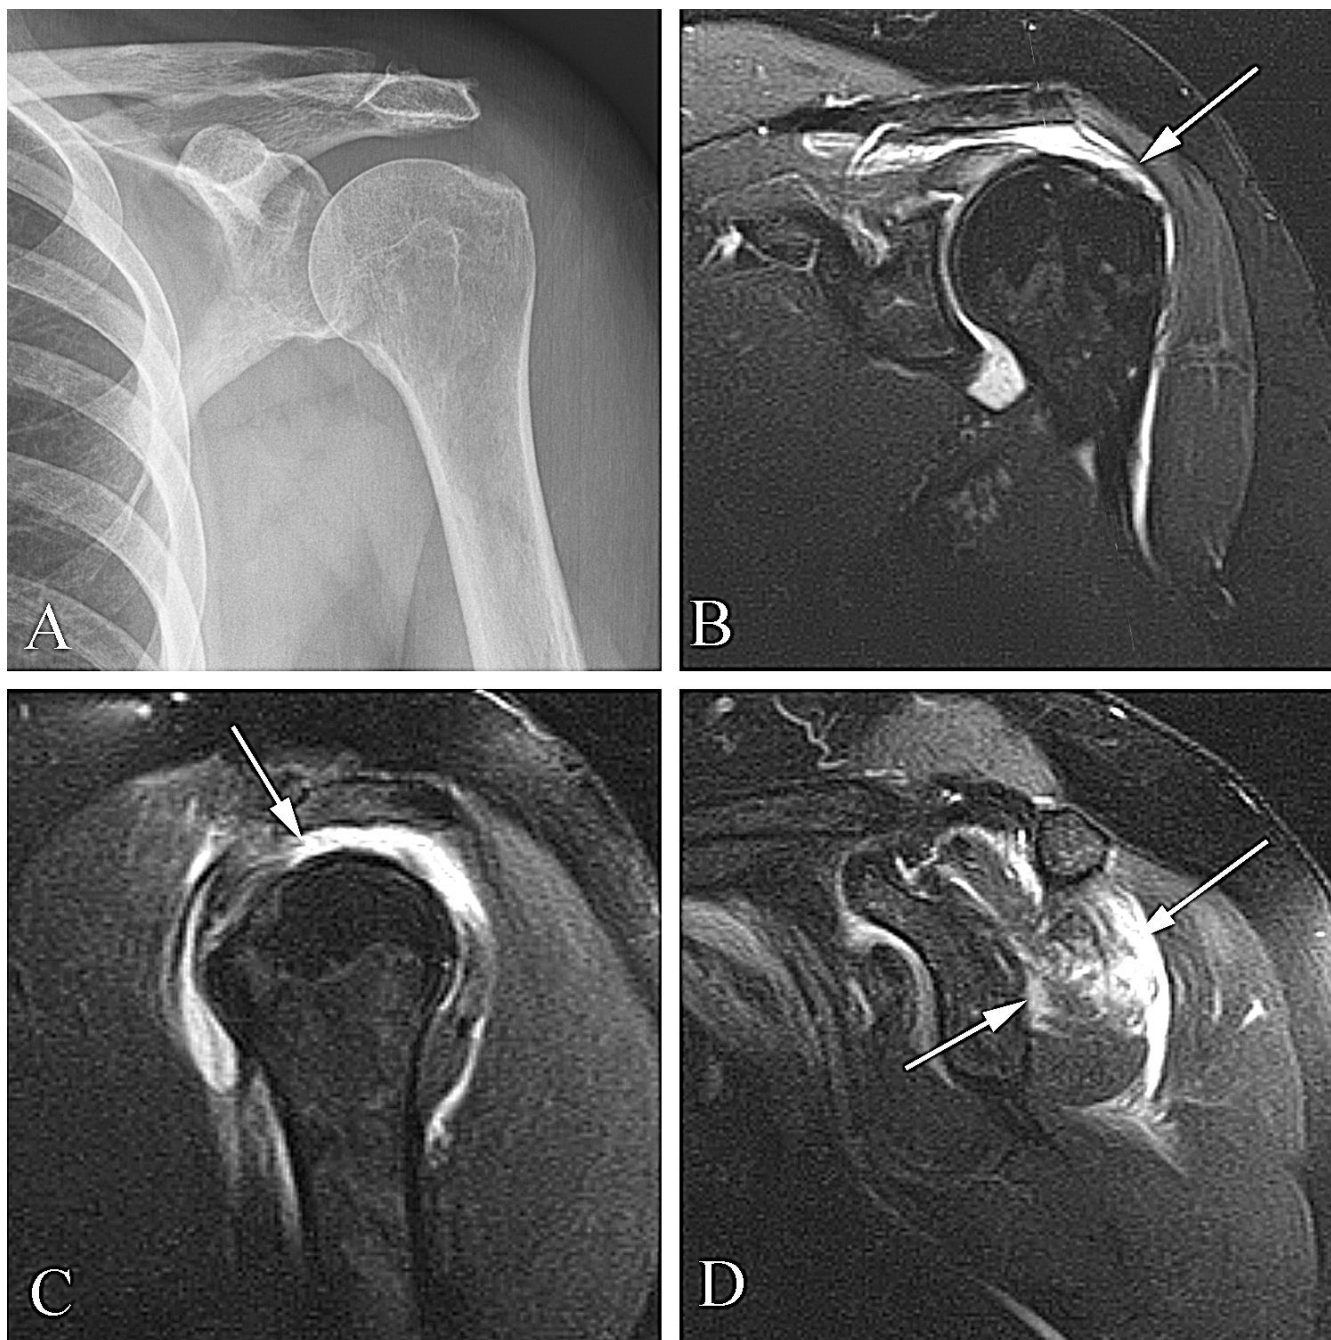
Acute rotator cuff tear in a 64 year old woman following trauma. A. AP plain film examination of the shoulder demonstrates no fracture. B. Coronal oblique fat-suppressed T2 weighted image shows a full thickness rotator cuff tear, with fluid along the normal course of the tendon deep to the deltoid muscle and superficial to the humeral head (arrow). C. Sagittal oblique fat-suppressed T2 weighted image demonstrates a large full-thickness rotator cuff tear (arrow) which involves both the supraspinatus and infraspinatus tendons. D. Sagittal oblique fat-suppressed T2 weighted image closer to the midline demonstrates extensive muscle tearing and interstitial increased signal (compatible with edema or hemorrhage) within the infraspinatus muscle (arrows).
